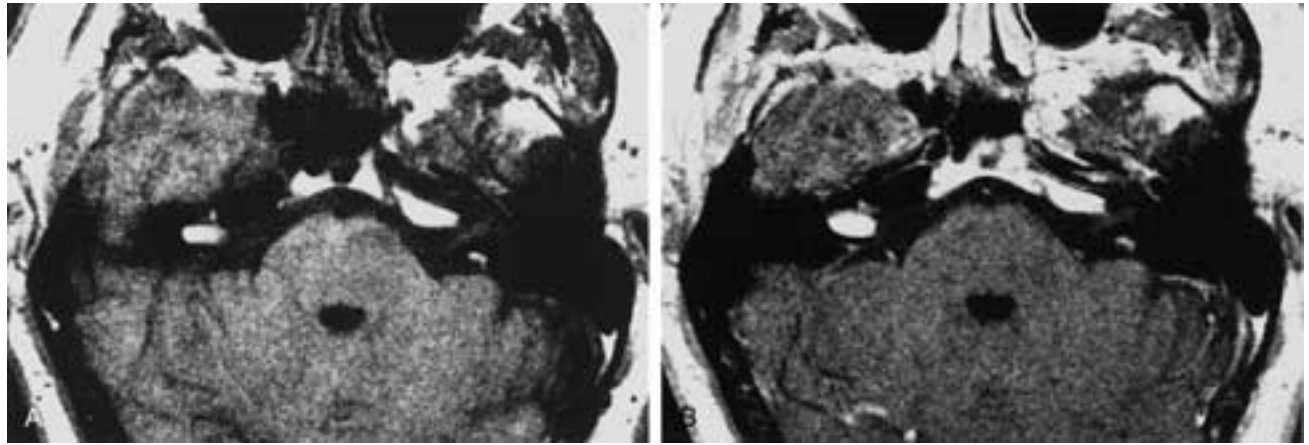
Lipoma of the right IAC. A, T1-weighted image without gadolinium enhancement. B, Gadolinium-enhanced T1-weighted image. The lipoma has high signal without gadolinium and does not change after contrast enhancement.
